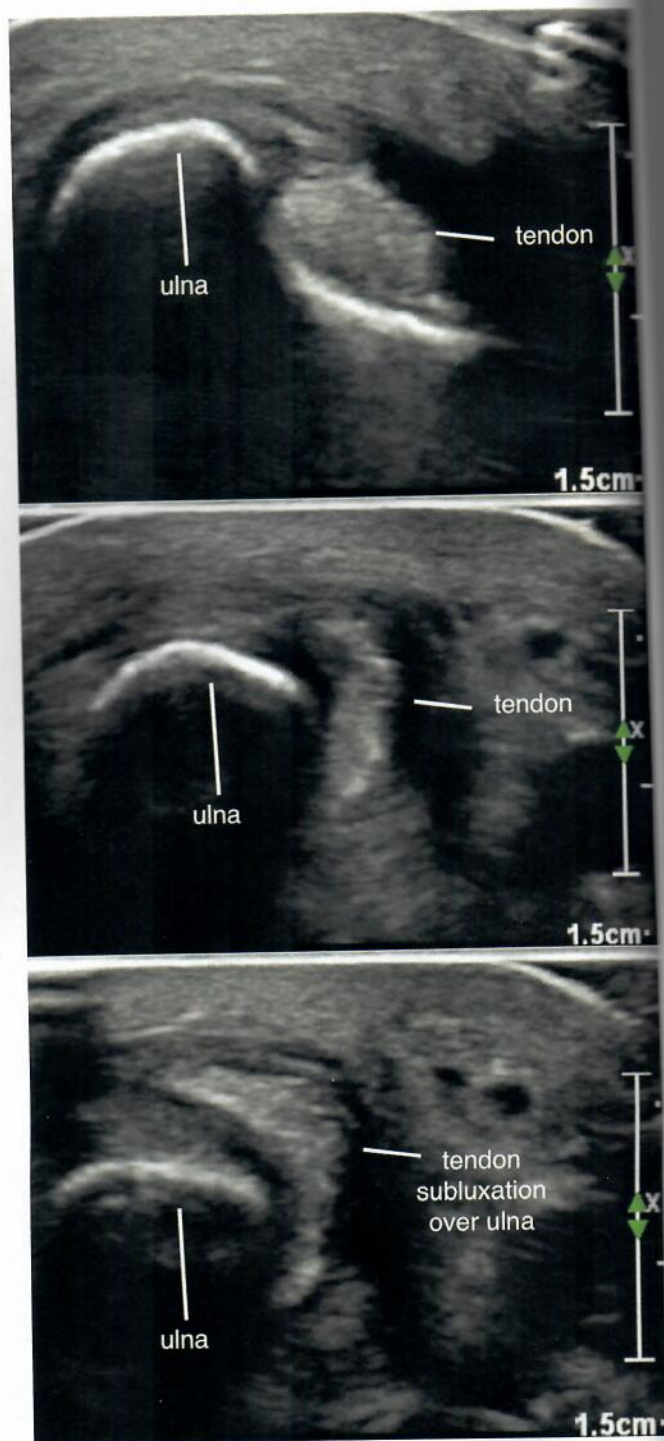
Ultrasound image of the wrist showing tendon subluxation as the wrist is moved from pronation where the tendon is in place (top), to neutral (middle, tendon moving) through to supination where the tendon is completely subluxed (bottom).
